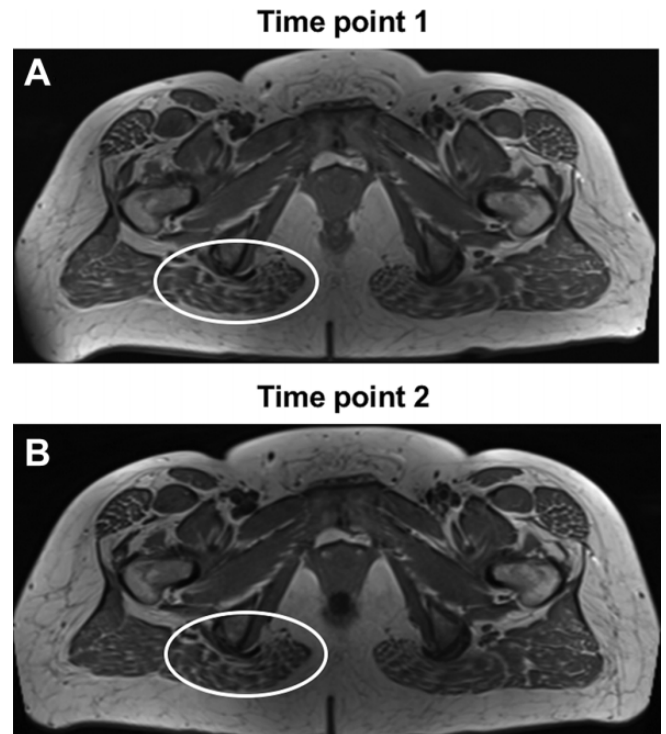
Axial Dixon magnetic resonance imaging scans of 1 participant showing (A) moderate atrophy of the gluteus maximus muscle (circles) at time point 1 and (B) no worsening at time point 2.
